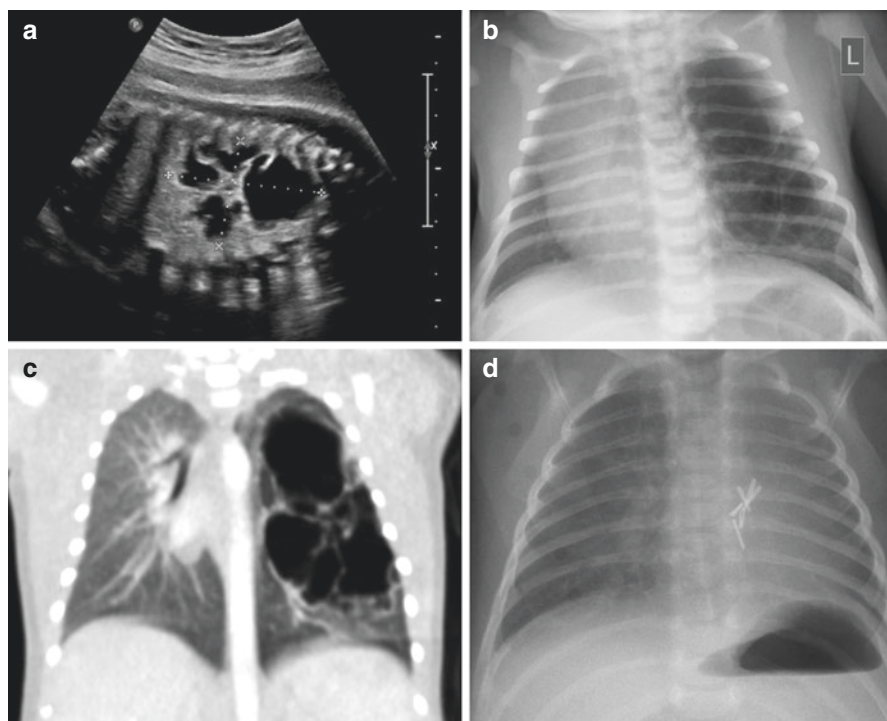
CPAM in a newborn, antenatally diagnosed in the 22nd Gestational week. Ultrasound scan during pregnancy (a). Postpartal chest X-ray (b). Postpartal CT scan with a mediastinal shift to the right side (c). Postoperative chest X-ray after thoracoscopic lower lobe resection on day 8 after birth (d)
